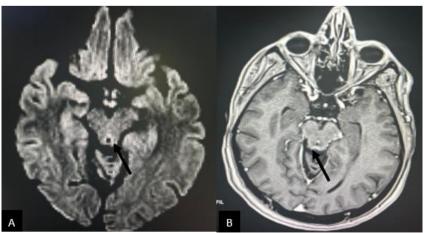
Diffusion sequence of a brain MRI in an 18-year-old child showing a hyperintensity of the tectal plate (A), and axial 3D T1 sequence after Gadolinium injection (B) showing moderate contrast enhancement at this level.
